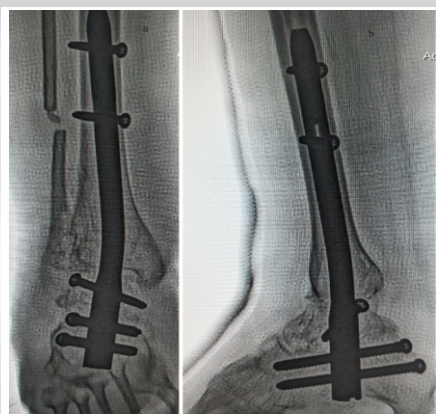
Radiograph of right ankle postoperative anterior posterior view (a) and lateral view (b) at 14 weeks.
